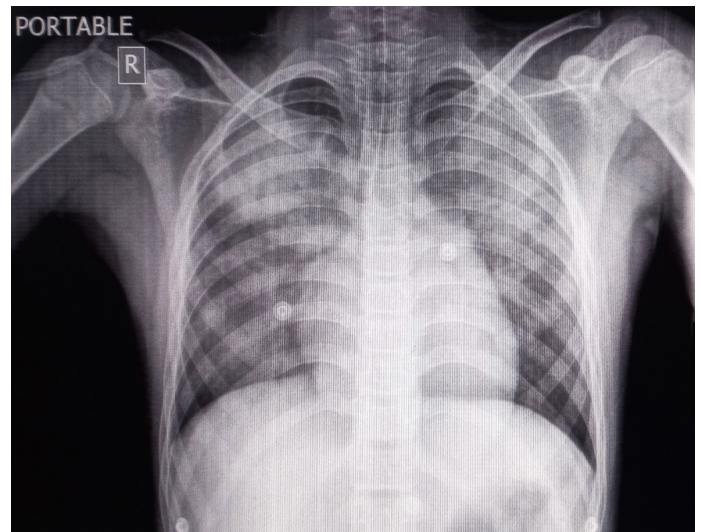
Portable chest X-ray with bilateral heterogenous opacities, suggestive of pulmonary edema, with ETT in situ, curved over the right bronchus
